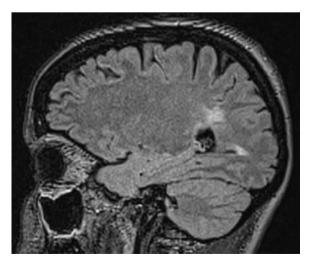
Sagittal MRI (FLAIR) that reveals hyperintense periventricular lesions in the white matter.
